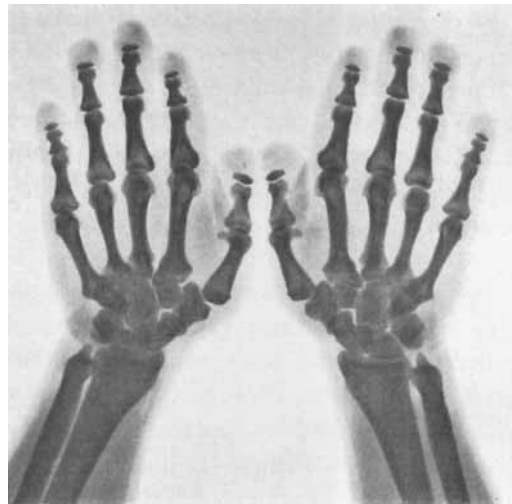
Roentgenogram of hands. Case 2. The terminal phalanges were extremely short. Cortex of the tubular bones was thick. Deformity of the base of the metacarpals was seen.
